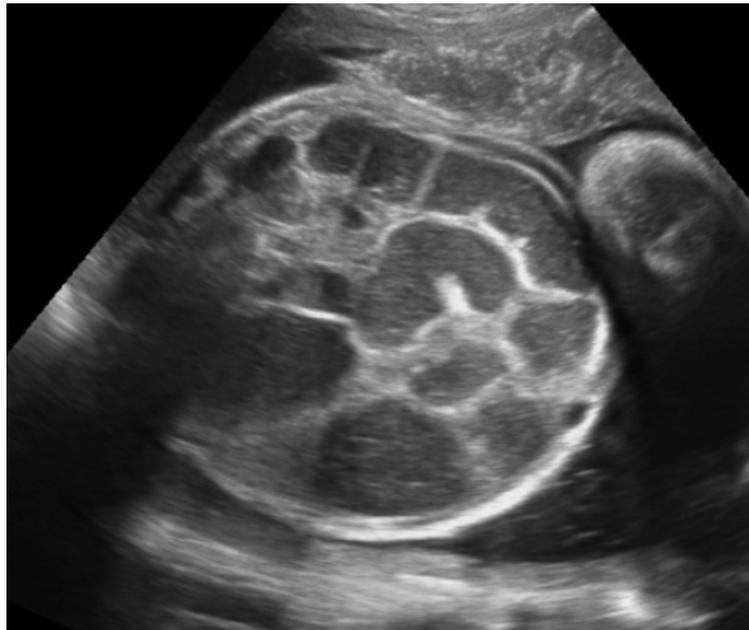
Preoperative ultrasonographic examination showed a 370 mm fetal abdominal circumference and an enlarged intestinal ring of 30 mm in diameter with intraabdominal calcifications at 38th gestational weeks
